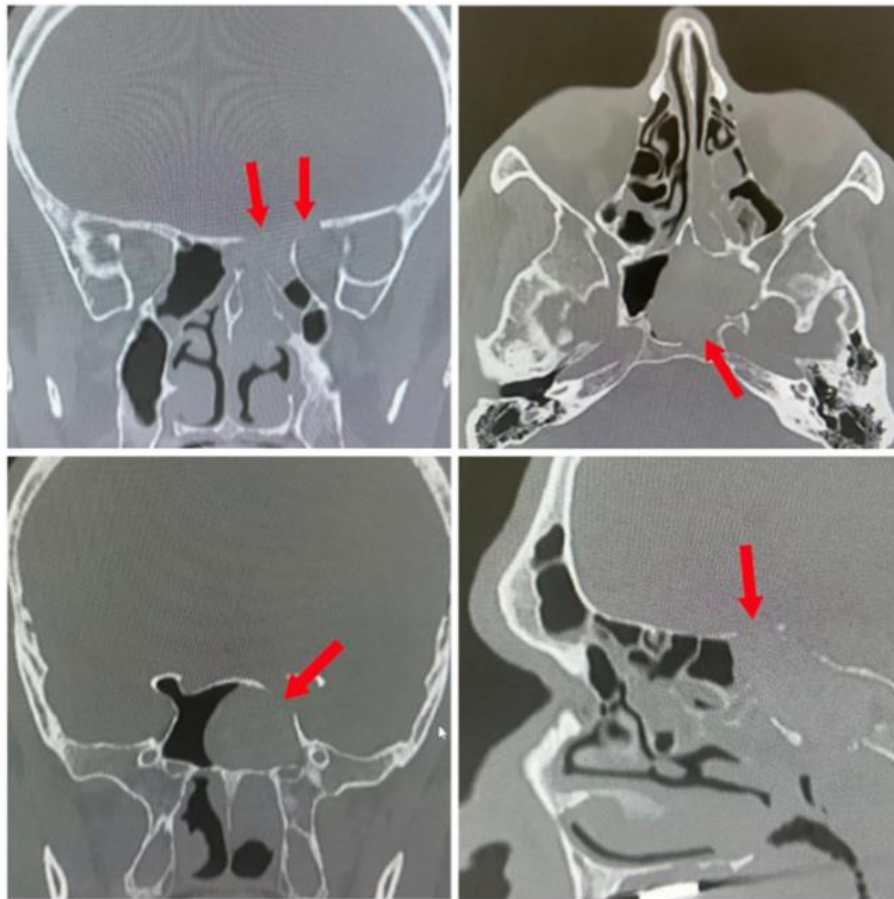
CT sections demonstrate pathological contents within the sphenoid sinus and posterior ethmoid air cells. Arrows indicate defects of the superior and posterior walls of the sphenoid sinus.
